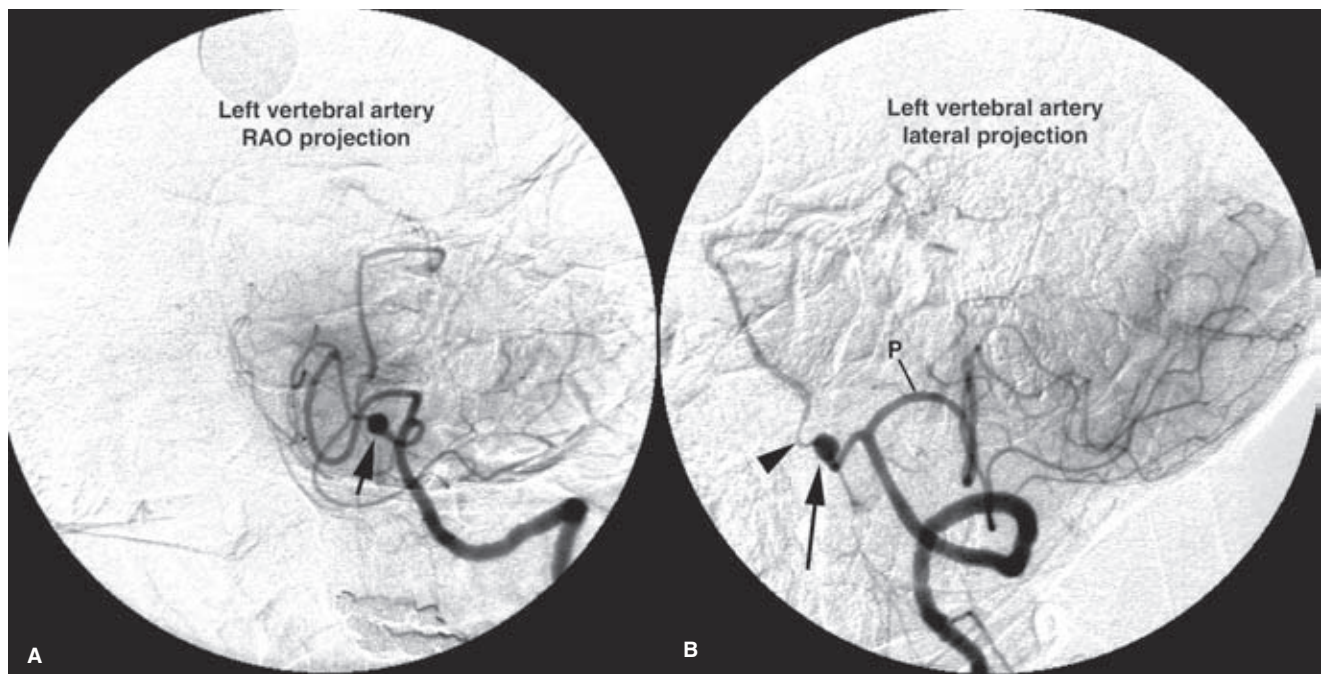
(A–B) Unruptured left vertebral artery dissection. A middle-aged female with complaints of headaches was found to have a suspicious flow void on MRI examination (not shown). A dissection at the vertebrobasilar junction demonstrated a focal area of aneurysmal widening (*arrow*) associated with extreme narrowing of the proximal basilar artery (*arrowhead*) above that level (“string and pearl”). The overlapping posterior inferior cerebellar artery (*P*) made the standard PA and Townes views difficult to interpret. The anatomy of the vertebrobasilar junction was clarified by these obliqued and skewed images.
